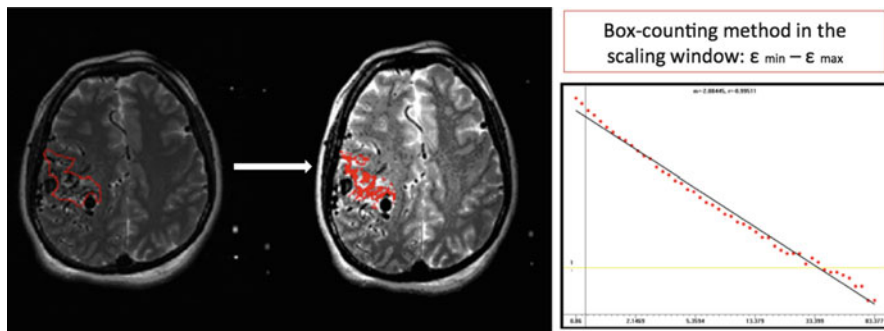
Computation of FD on MR images of AVMs. The region of interest of the AVM is manually segmented on each slice, and an RGB threshold is used for the computer-aided segmentation of the vessels forming the nidus. The box-counting method is then applied in the fractal window, and the results are plotted on a graph, the slope of which represents FD (From Di Ieva et al. [8], reprinted with Permission of the Publisher)
